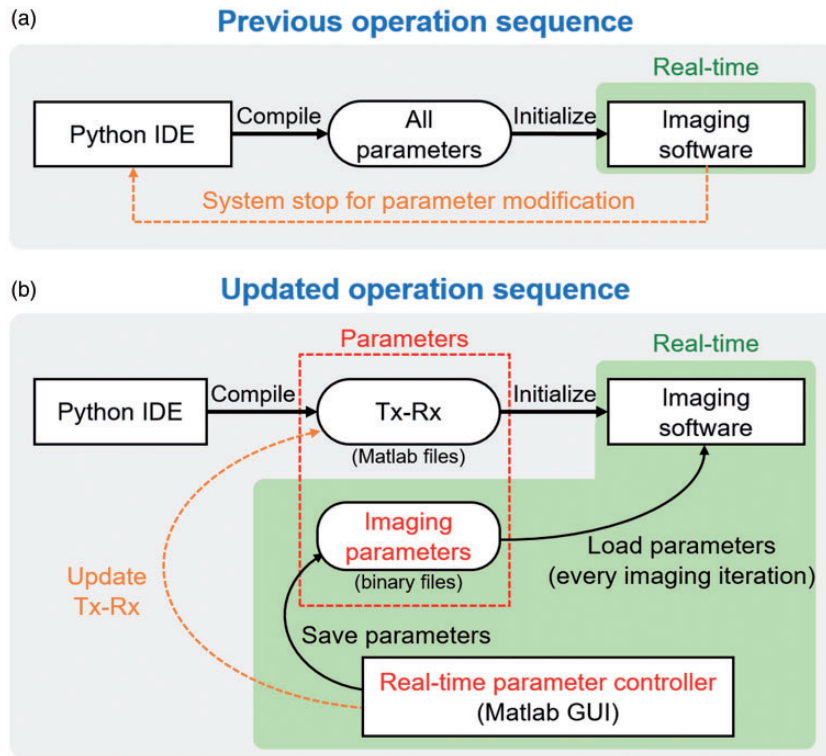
Previous (a) and updated (b) operation sequence for parameter modification in the ultrasound machine. Green boxes denote real-time operations. IDE: independent development environment; Tx: transmission; Rx: reception; GUI: graphical user interface. (A color version of this figure is available in the online journal.)
